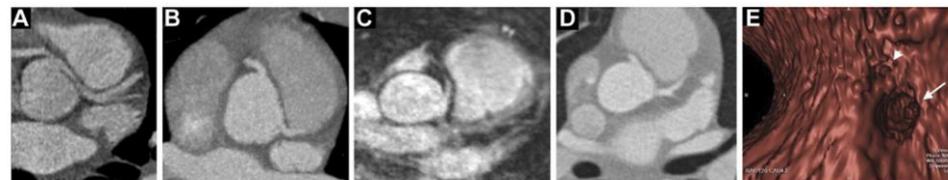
(A) A computed tomography scan shows a left anomalous aortic origin of the left coronary artery (AAOCA). (B) Scan shows the same patient after coronary unroofing. The coronary orifice has been moved to the left sinus of Valsalva and appears widely patent. (C) A computed tomography scan shows a right AAOCA. (D) Scan shows the same patient after coronary unroofing. (E) A computed tomography scan shows an endoluminal view of a right AAOCA from the left sinus with a normal left coronary artery ostium (white arrow) and slit-like right coronary artery (white arrowhead).
